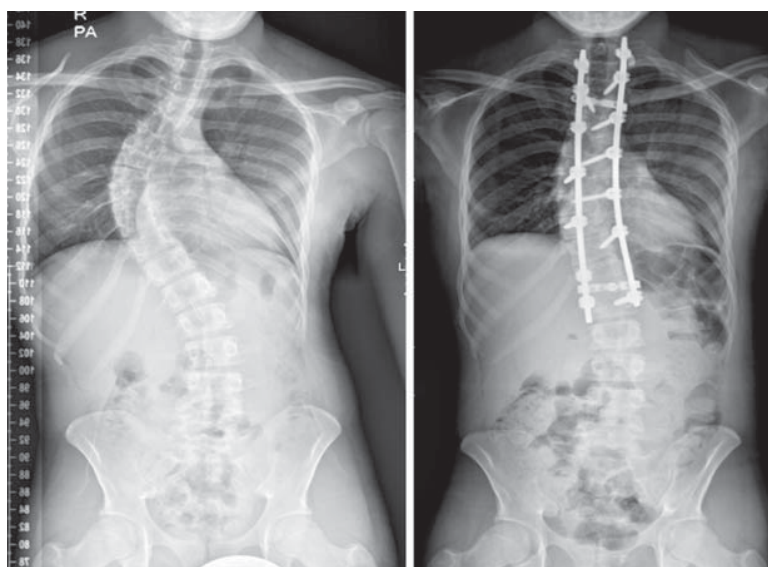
Preoperative (left) and postoperative (right) radiographs of an adolescent boy with idiopathic scoliosis, showing correction of the scoliosis by posterior instrumented fusion of the spine
